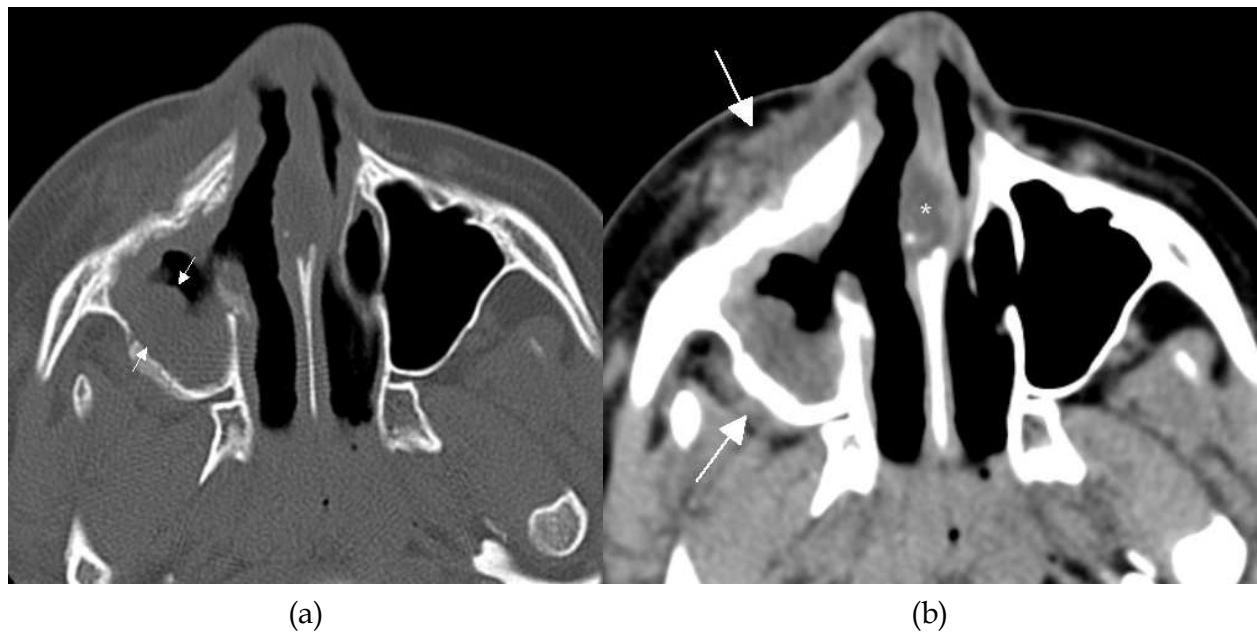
(a) Axial CT with bone algorithm shows right maxillary sinus with advanced mucosal thickening (arrows) surrounded by sclerotic bone. (b) Axial CT with soft tissue algorithm reveals preantral and postantral soft tissue masses (arrows) due to invasive sinusitis. Notice also the septal thickening referred to as an eschar (asterisk).
